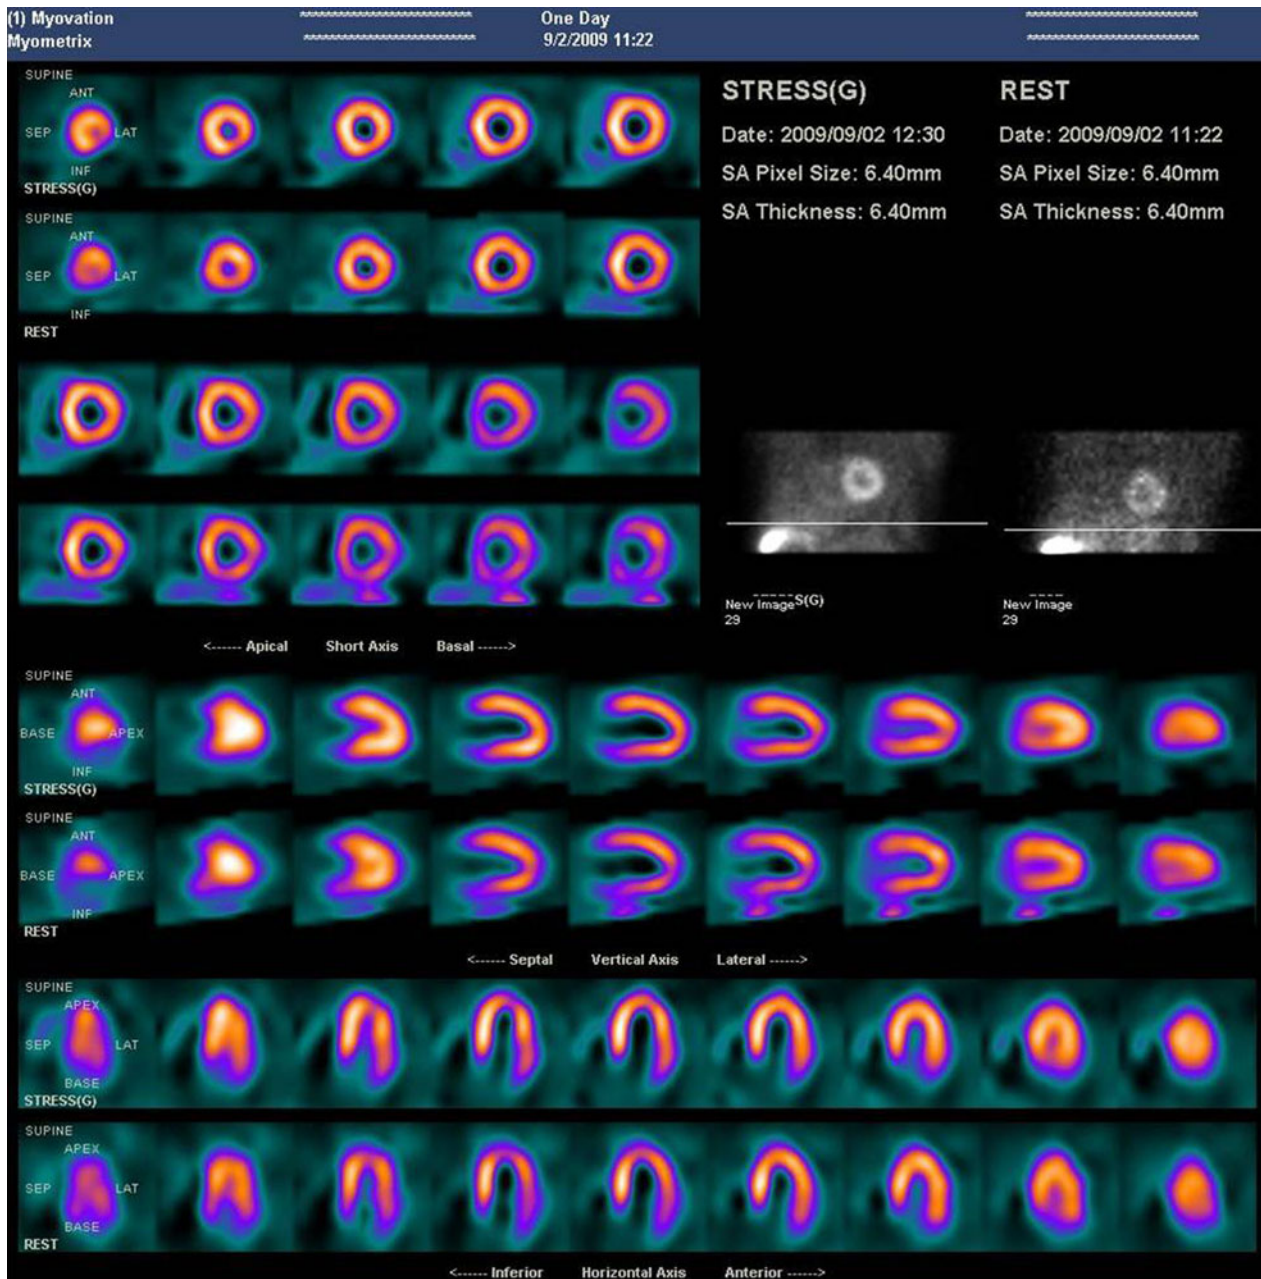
WBR[®] “half-time” Xpress[®] software was used to reconstruct this reduced-dose rest/stress (6.2/17.3 mCi) Tc-99m sestamibi “full-time” SPECT scan in a normal male patient with a 38” chest circumference. Image quality is excellent and comparable to a “full-dose,” “full-time” study processed with OSEM iterative reconstruction⁴⁶.
